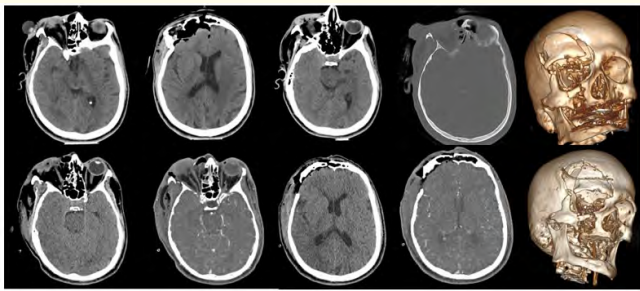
The upper line: Preoperative CT images demonstrate deformed and anteriorly-laterally displaced right bulbus oculi.
